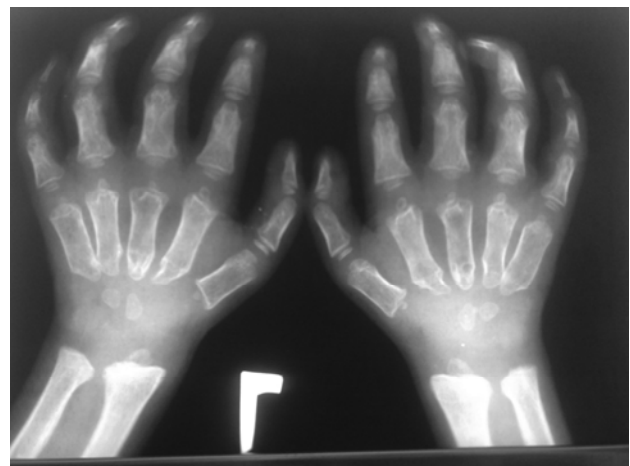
Radiography of patient's wrists.
